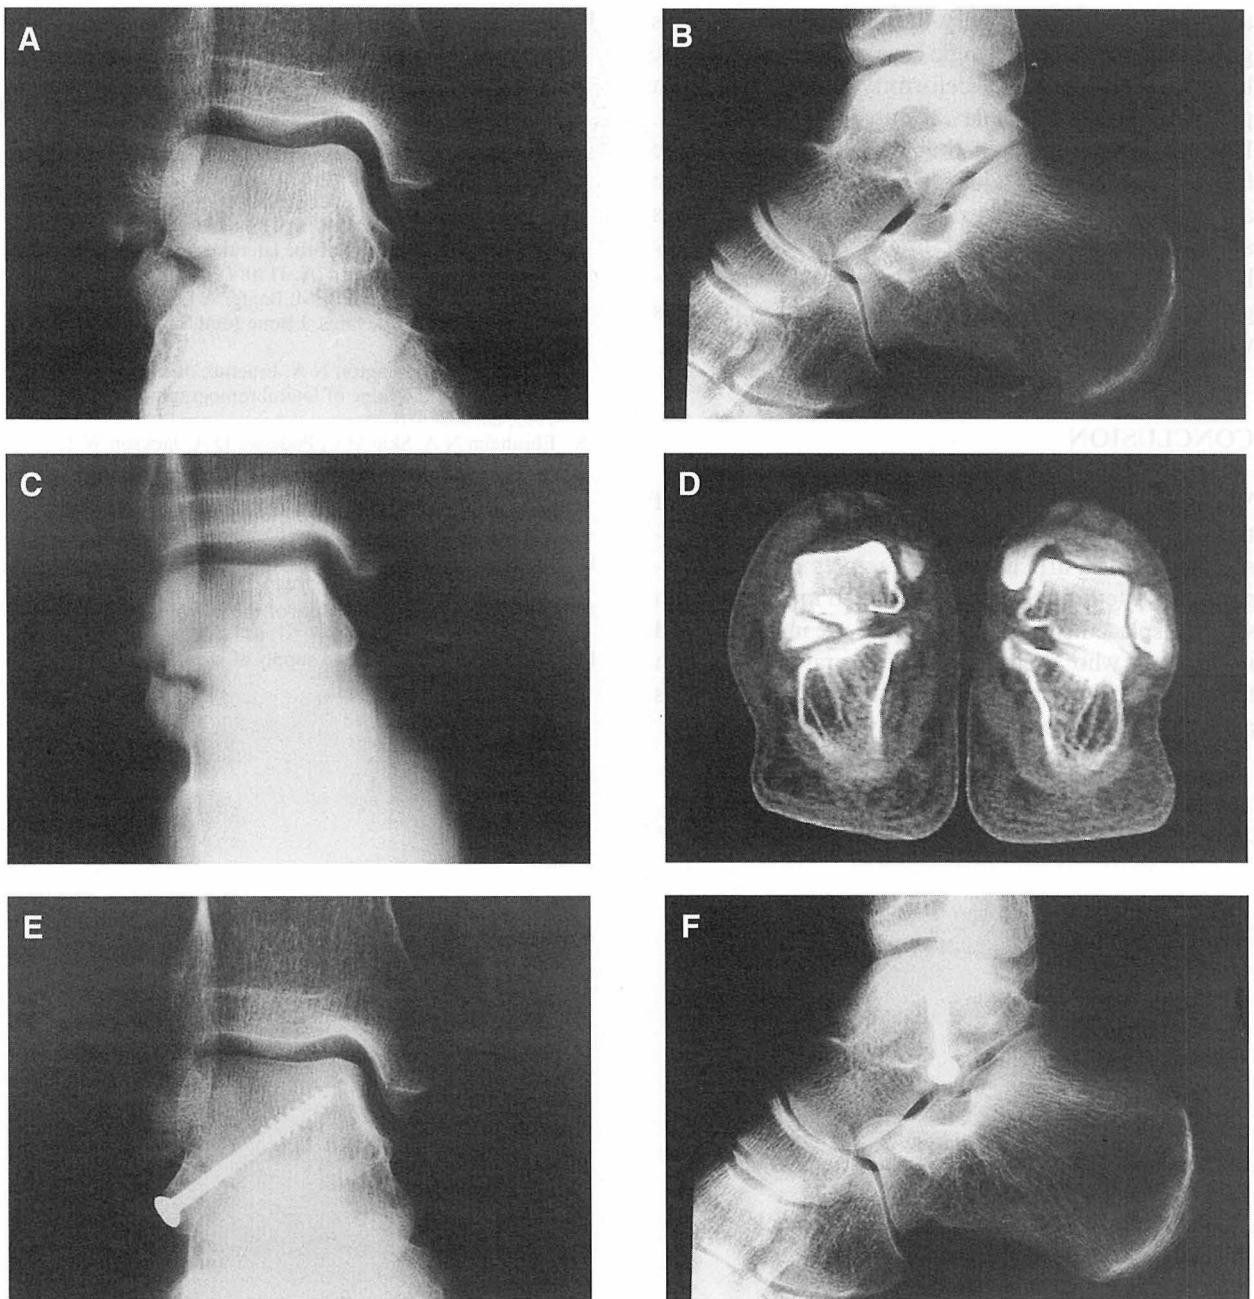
Case 6. 59-year-old woman. Intra-articular-type fracture. The anteroposterior view (A) shows a large fragment of the lateral process of the talus. However, it is difficult to identify it in the lateral view (B). Tomographs (C) and CT scans (D) clearly show the size and displacement of the fragment. A postoperative anteroposterior view (E) and lateral view (F) confirmed that repositioning of the fragment was anatomical and that internal fixation by malleolar screw was rigid.
